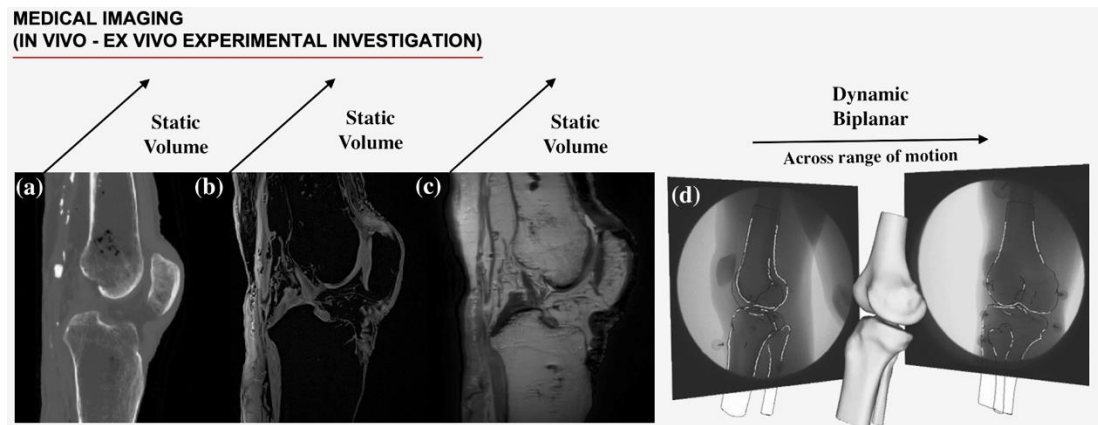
Medical imaging modalities: (a) CT Scan, (b) MRI T1 Vibe Sequence, (c) MRI Proton Density Sequence, and (d) Biplanar Fluoroscopy. Figure (d) has been reprinted with minor adaptations from *The American Journal of Sports Medicine*, with permission from SAGE Publications, Inc. (Myers et al., 2012).
